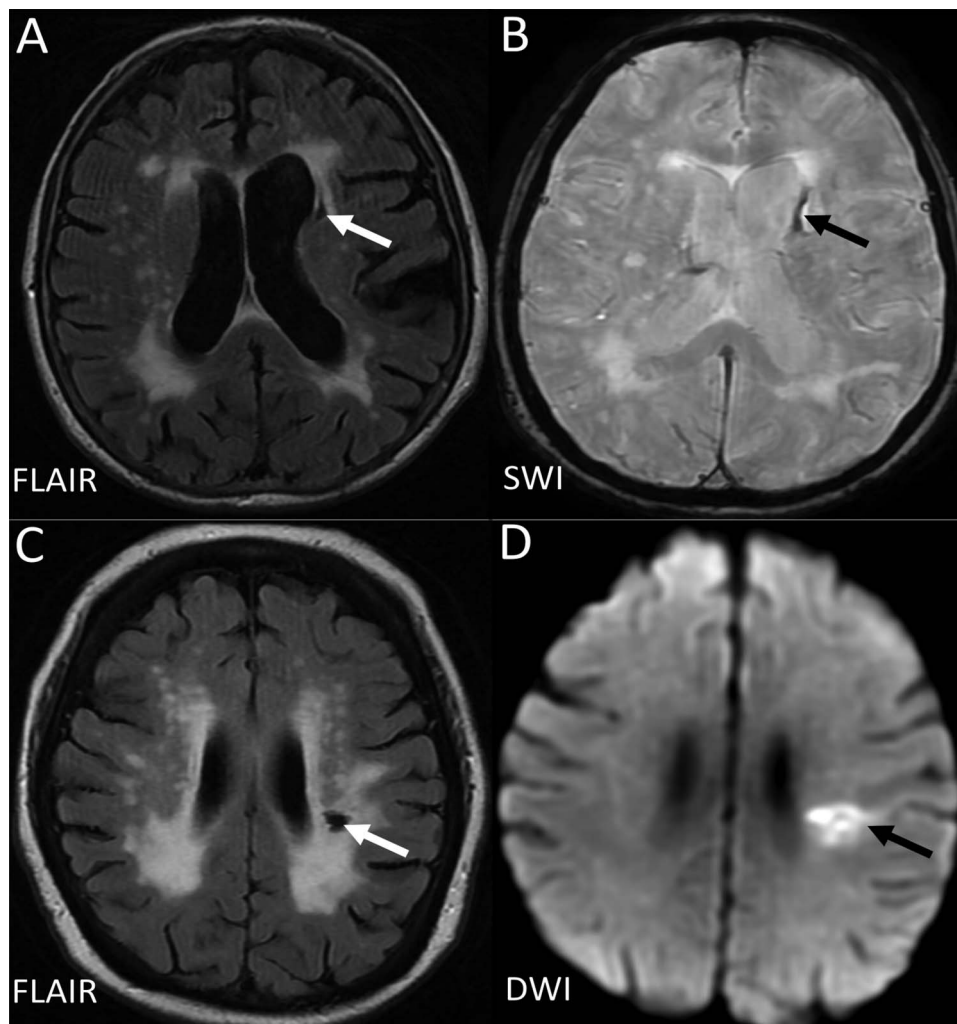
Example of MRIs of a lacune from a haemorrhagic source (A,B), and from a lacunar infarct (C, D). D (the DWI) is from the acute presentation (i.e. within a few days of the stroke), and C (the FLAIR) is weeks to months later when the lesion has cavitated. DWI, diffusion-weighted imaging; FLAIR, fluid-attenuated inversion recovery; SWI, susceptibility-weighted imaging.
